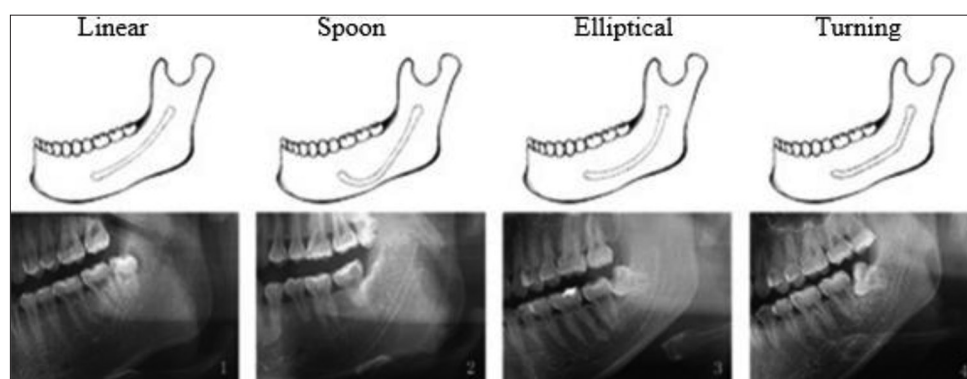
Shape of inferior alveolar canal. (Courtesy: Inferior alveolar canal course: A radiographic study; Liu *et al.*)²³
